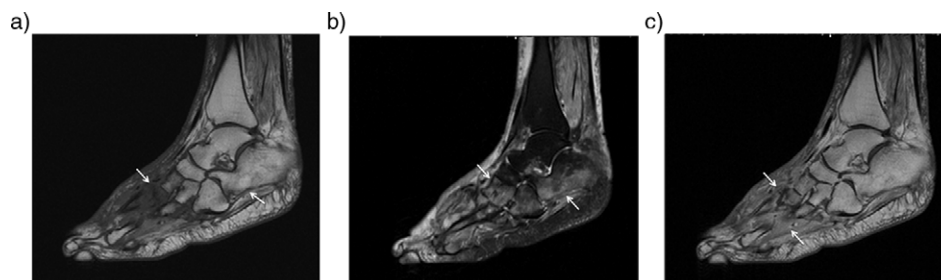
Acute neuropathic arthropathy of the foot of 53-year-old woman with diabetes. Sagittal T1 (a) and T2-weighted fat saturated images (b) reveal diffuse bone marrow edema around the Lisfranc joint and calcaneus (arrows). There is also a subcutaneous soft tissue edema especially in the dorsum of the foot. Contrast enhanced sagittal T1-weighted image (c) shows increased enhancement in bone marrow and periarticular tissue (arrows). No evidence of fluid collection or sinus tract noted.
